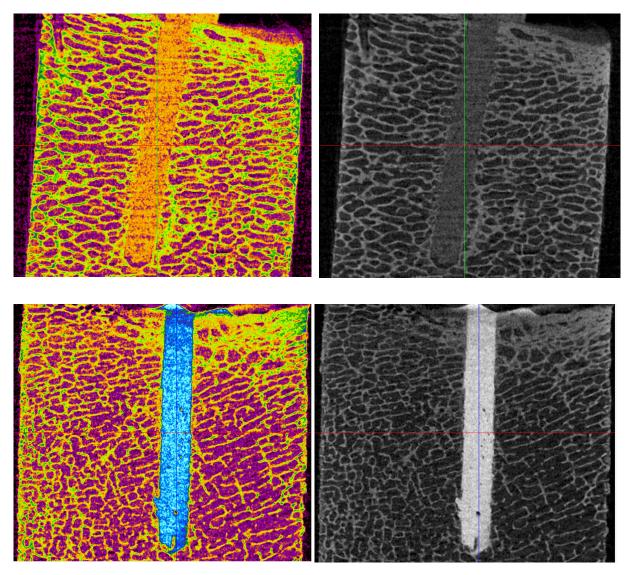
$\mu CT$  scans to show that the injection technique is good enough to avoid the formation of big air bubbles.
